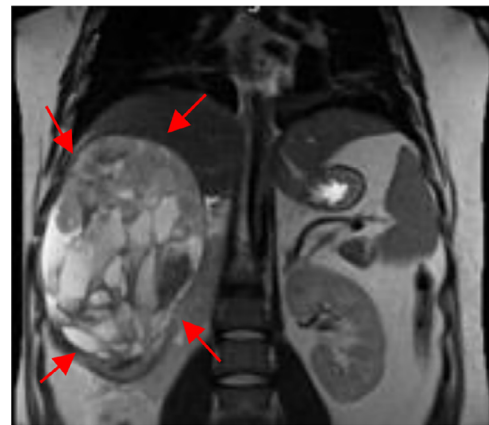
T2 Coronal MRI showing hepatic mass with complex internal components (red arrows).
